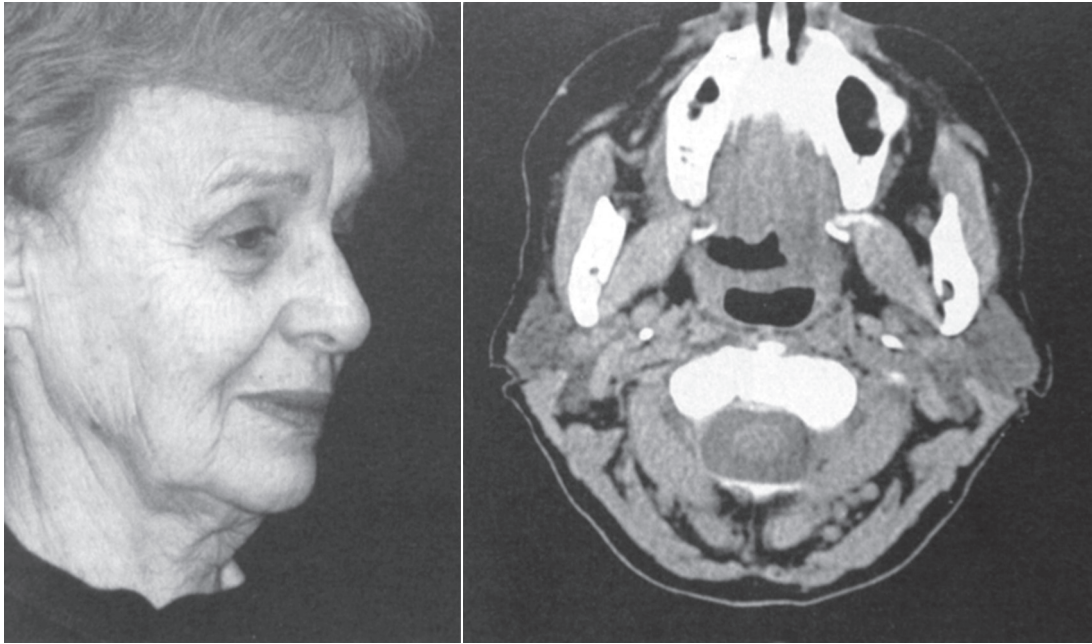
The facial anatomy of a 42-year-old female (+CT scan).
